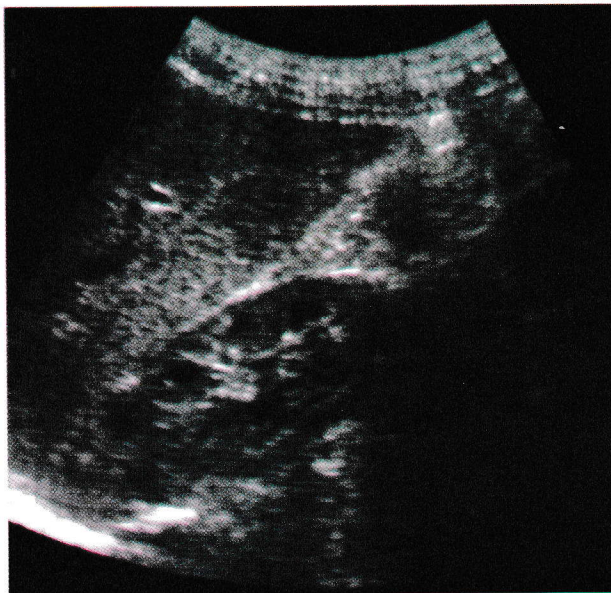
Abdominal sonogram of DT showing the liver in the left hypochondrium and the left kidney. Both organs demonstrate normal anatomy and echopattern.
